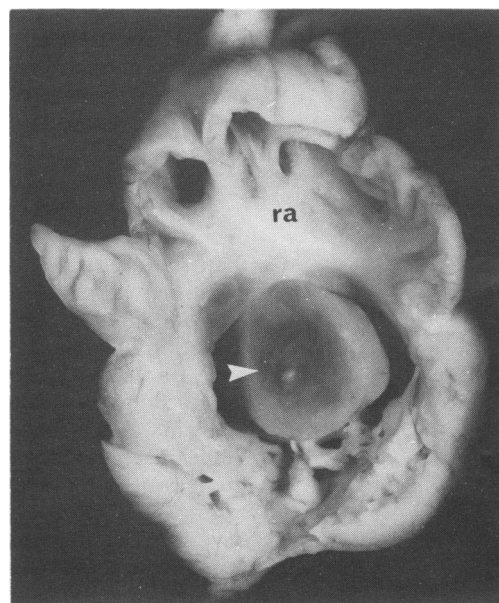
The fetal heart opened at postmortem examination demonstrates a rhabdomyoma (ra) attached to and obstructing the orifice of the tricuspid valve (arrow). This correlated well with echocardiographic appearance.
